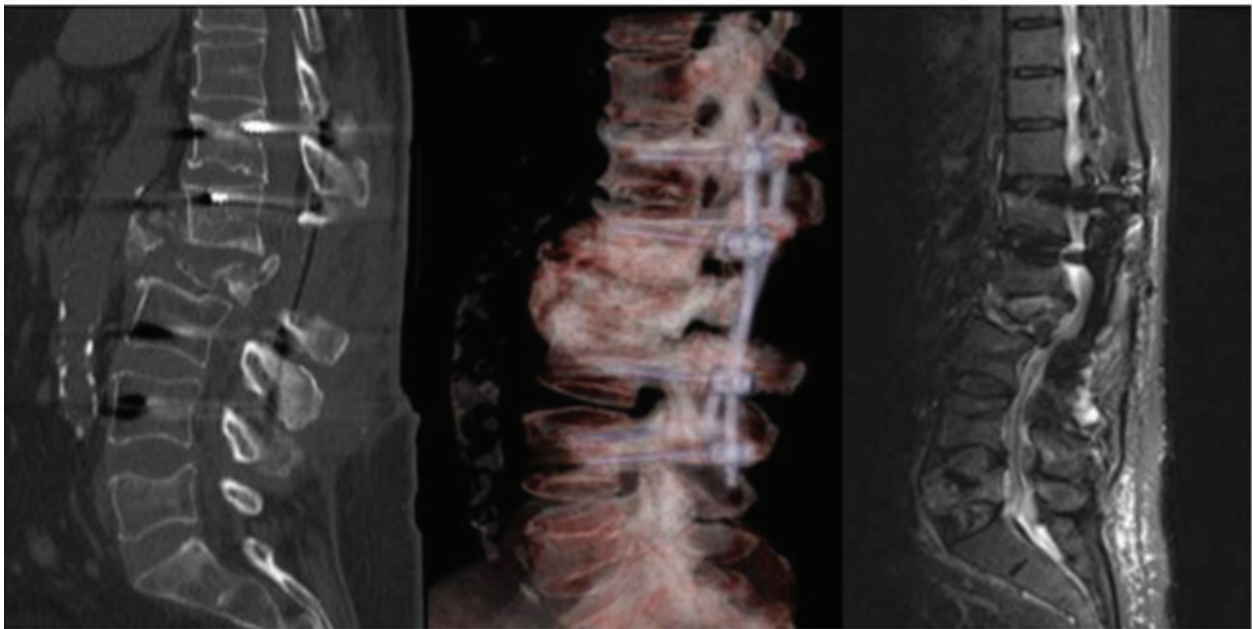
Preoperative computed tomography scan, with reconstruction, and magnetic resonance imaging.
